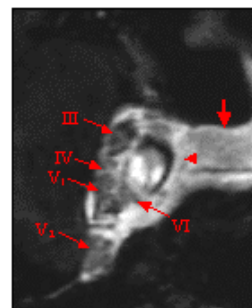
T1-weighted contrast enhanced 3D-MP-RAGE 3T MR image: Right cavernous sinus. Cranial nerves III (inside CSF-filled dural sheath), IV, V1, V2 and VI visible inside lateral wall (long arrows), medial cavernous sinus border (short arrow) pituitary gland (arrow).
